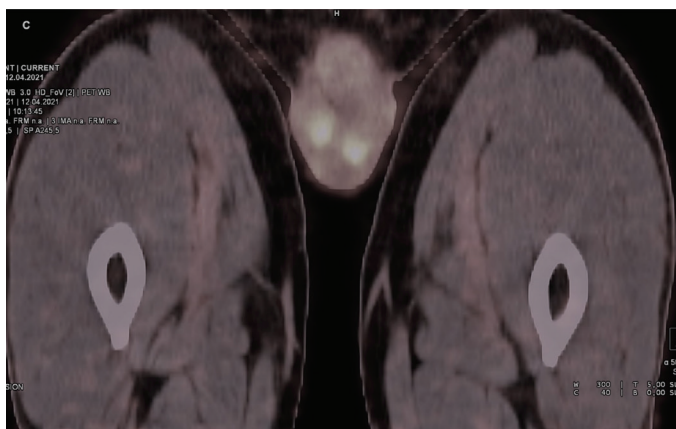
18F-FDG PET/CT image of testicular adrenal rest tumors
